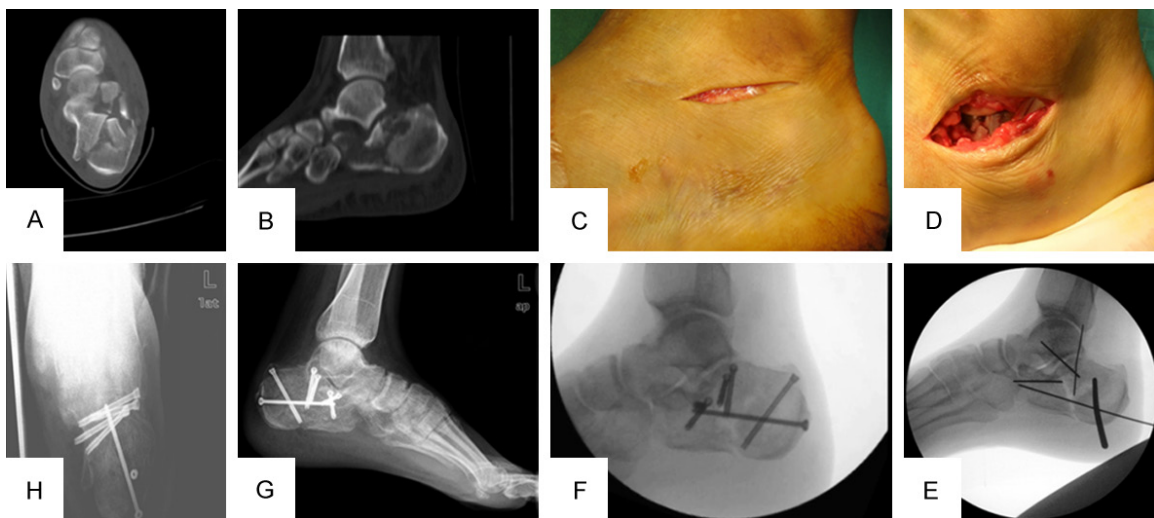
Percutaneous fixation via a small sinus tarsi approach. The photograph and radiograph of the small sinus tarsi approach. Preoperative lateral X-ray showed the intra-articular calcaneal fractures, with decreased calcaneal height, Gissane angle, and Böhler angle (A, B); an incision was made from the tip of the medial malleolus to the bases of the fourth metatarsals to expose rupture and collapsed articular surface (C, D); After traction, poking reduction, Kirschner wire was used to fix temporarily (E) followed by screw fixation (F); Postoperative X-ray showed that the calcaneal height, Böhler angle, Gissane angle, and calcaneal width were recovered (G, H).
